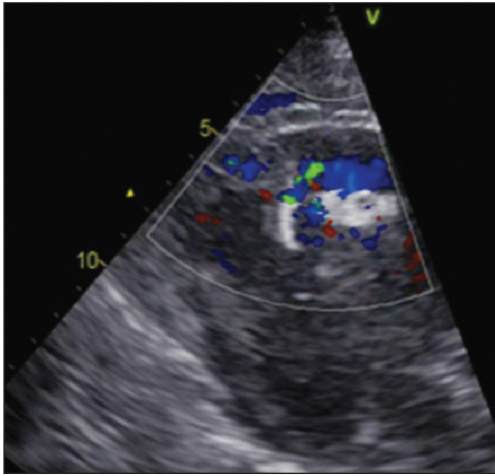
Transthoracic echocardiography demonstrated that the device was in a good position with a minimal residual shunt.
